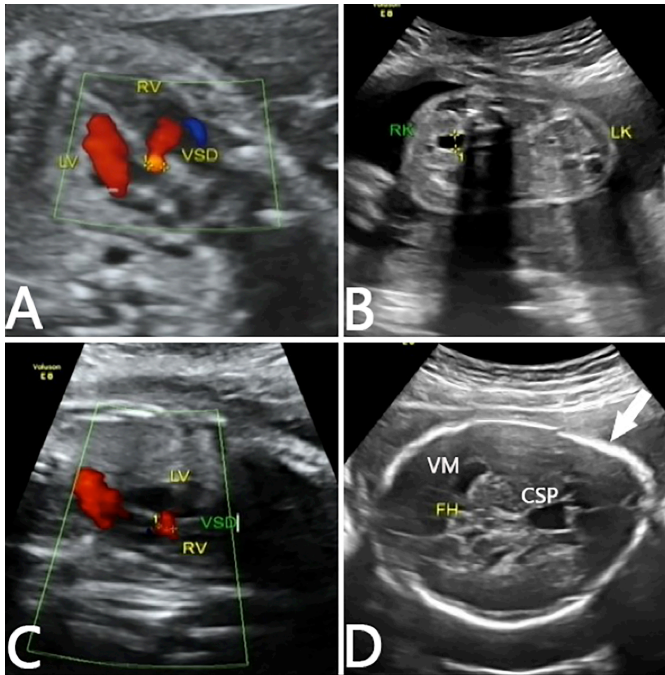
Prenatal ultrasound findings in the study. (A) Ventricular septal defect in case 1; (B) Pyelectasis in case 2; (C) Ventricular septal defect in case 2; (D) Trigonocephaly or 'lemon-shaped' skull (solid white arrow), dilation of the septum pellucidum cavity (CSP) and ventriculomegaly (VM) in case 2.
